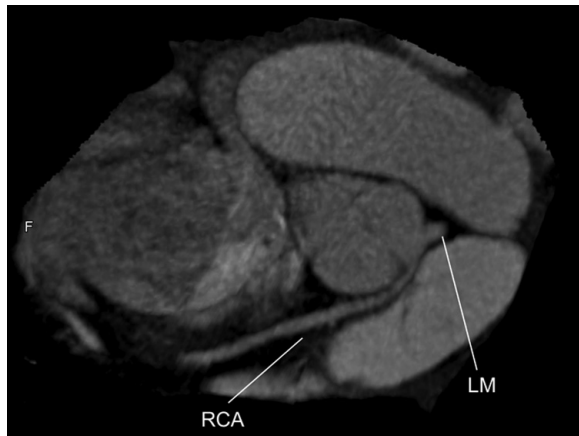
Preoperative cardiac computed tomography angiogram showing the right coronary artery (RCA) originating from the left sinus of Valsalva. LM indicates left main coronary artery.
